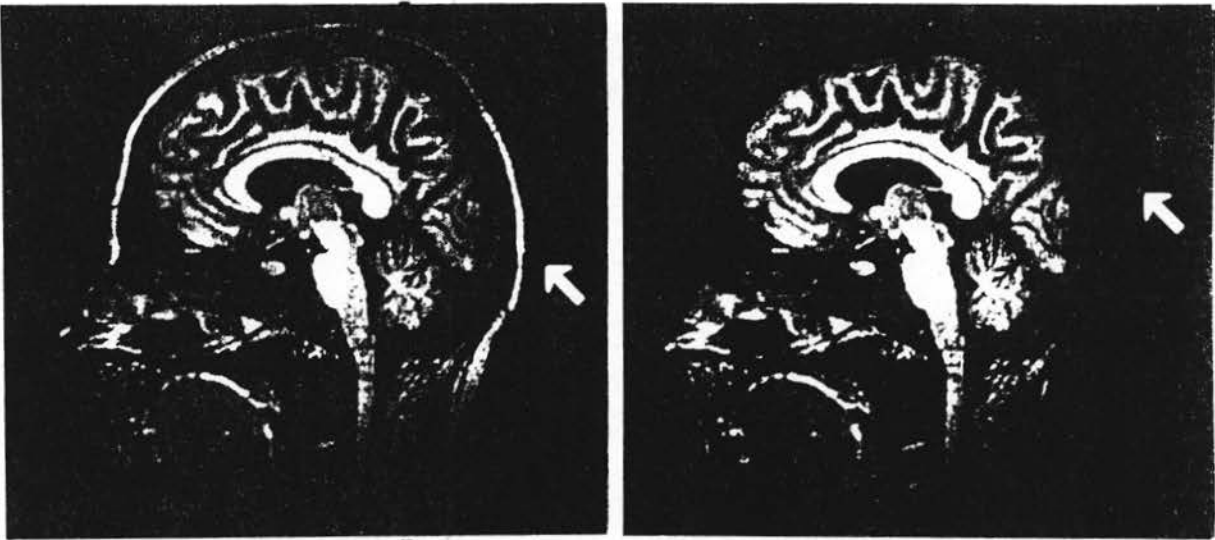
Sensible region computed via Intensity Axis of Symmetry of 3D MRI data (MRI data courtesy of Siemens).
